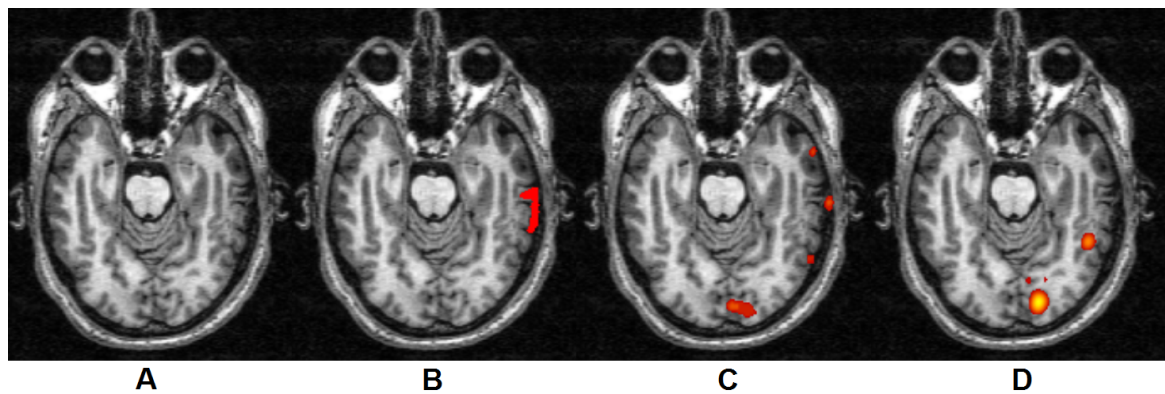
Patient P0836 MRI scan (A) manual delineation (B) comparison with result of automatic delineation (D). Also showing found missing tissue TPM (C).
